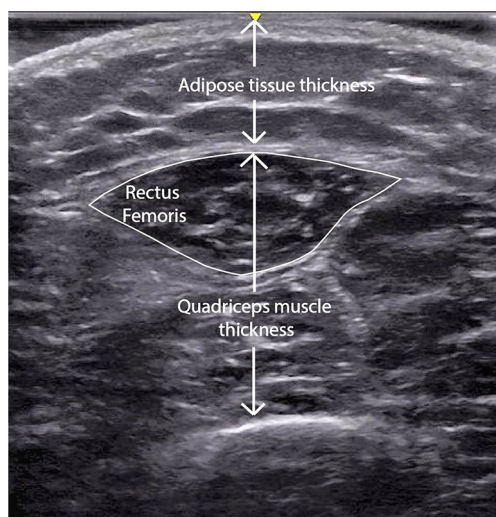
Ultrasound image of a rectus-femoris cross sectional area. Arrows depict the quadriceps muscle thickness and adipose tissue thickness. Solid white outline depicts the rectus femoris cross-sectional area.
